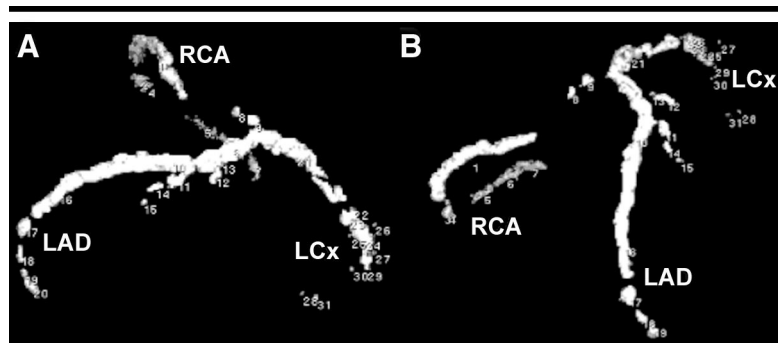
Coronary calcification scoring. *A*, Left lateral and, *B*, left anterior oblique projections of the distribution of plaques detected (numbered) during scoring of atherosclerotic coronary calcification with nonenhanced four-detector row CT. Because of the extent of coronary calcification, outlines of LAD, left circumflex (LCx), and dominant right (RCA) coronary arteries are formed.
